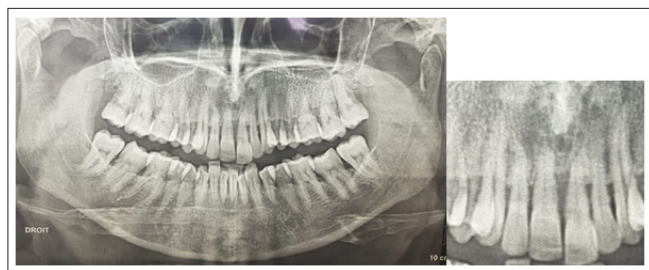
Panoramic radiograph showing severe bone resorption of the maxillary incisors (11.12.21.22) extended to the apical third.
